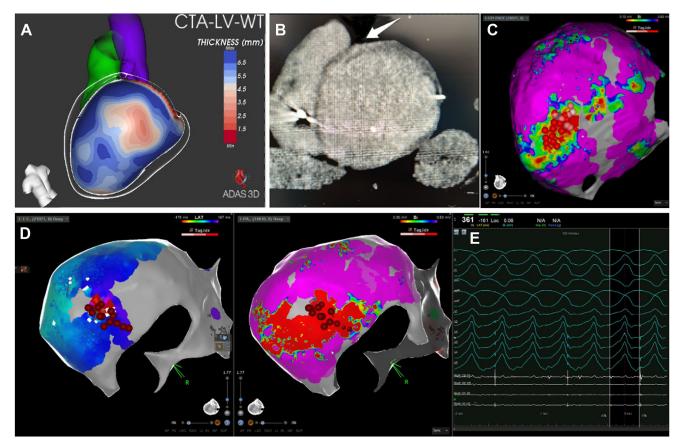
A: Contrast-enhanced computed tomographic scan before first ablation displays an ischemic scar at the lateral wall. B: Late contrast enhancement in the septum (*arrow*). C: First substrate-guided ventricular tachycardia (VT) ablation, both endocardial and epicardial. D: Second ablation activation and voltage map with pulsed-field ablation applications (*dots*). E: Hemodynamically unstable VT and electrogram at the ablation site.
